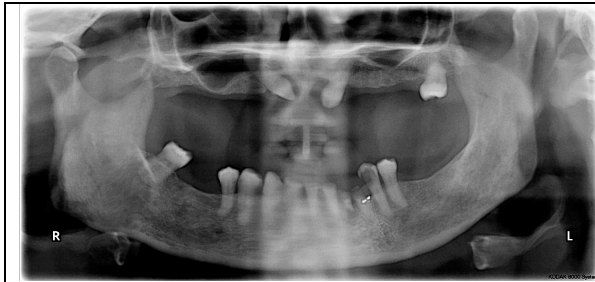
Radiographic Orthopantomogram (OPG)
